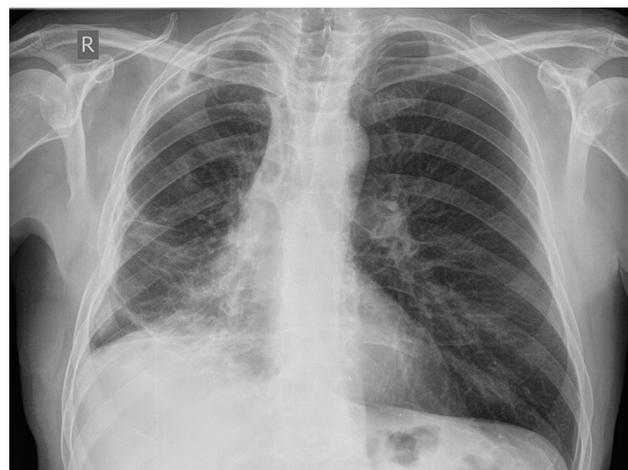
Chest X-ray one month after the surgery showing expanded right lung.
